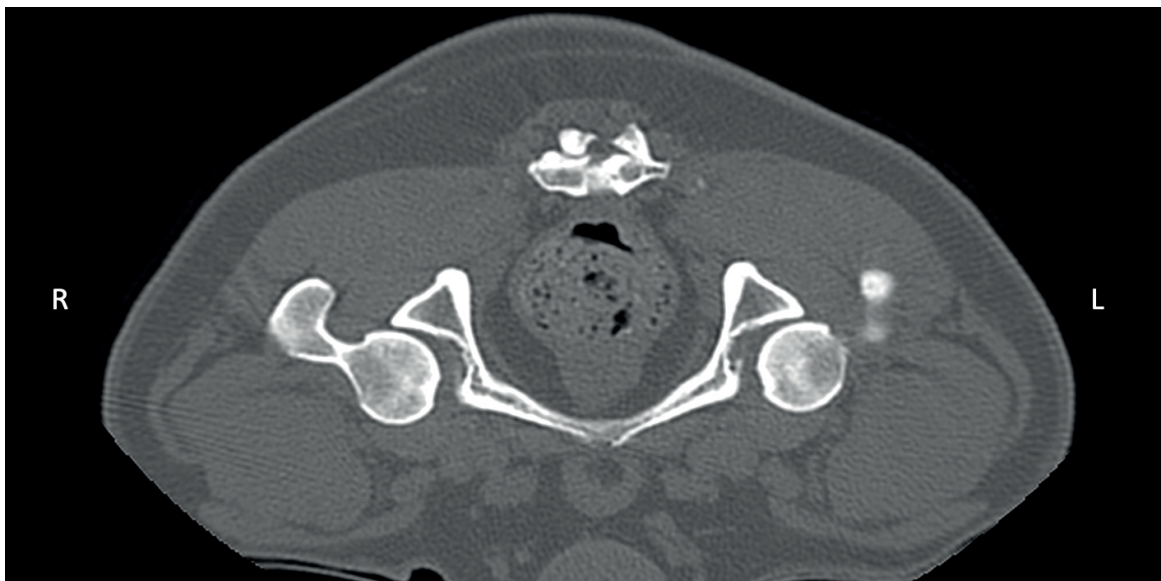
Transversal pelvic CT image of 7 years old, male, Golden Retriever. bilateral hip dysplasia and moderate osteoarthritis at acetabulum. R: Right, L: Left.
